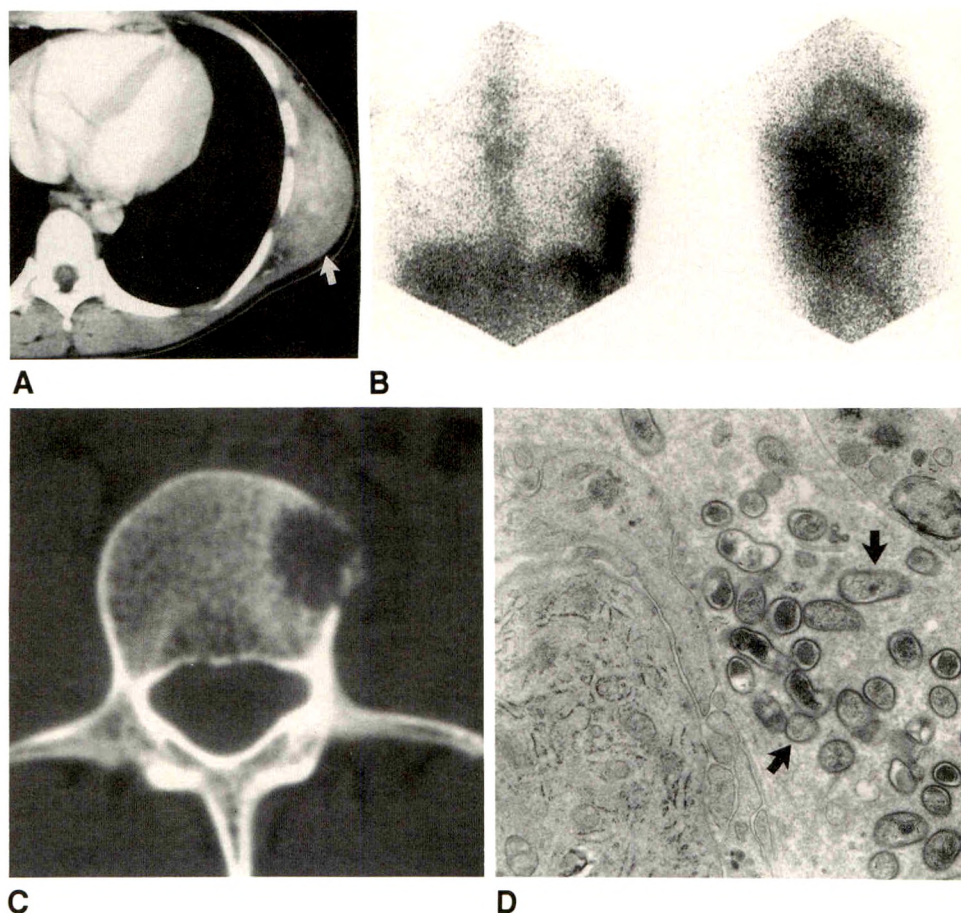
A, Contrast-enhanced CT scan shows a vascular heterogeneously enhancing mass (arrow) in left side of chest wall in patient positive for human immunodeficiency virus.
